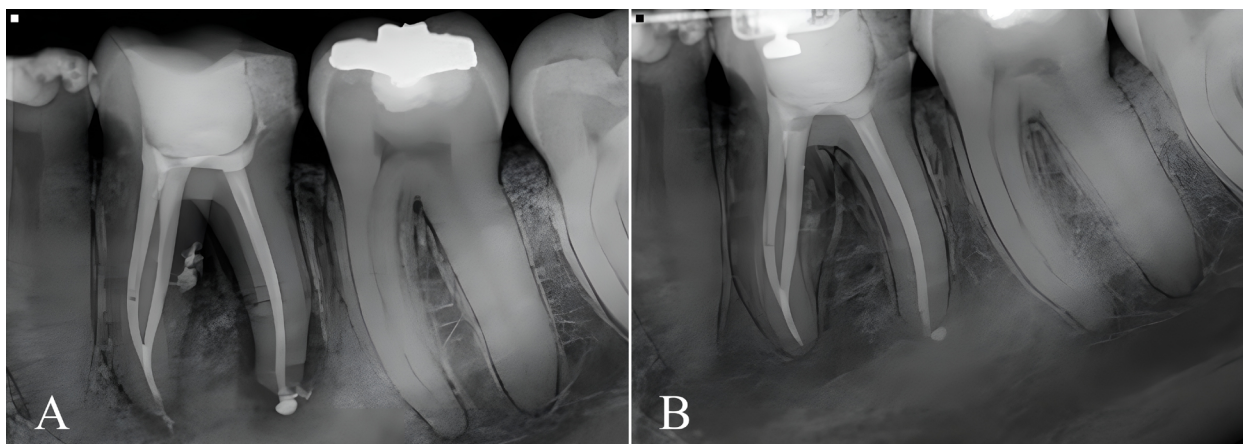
Representative images of the outcome of endodontic treatment performed with foraminal cleaning. A: Radiograph taken immediately after treatment; B: Radiograph taken 12 months post-operatively, classified as Score 1 (complete healing).
